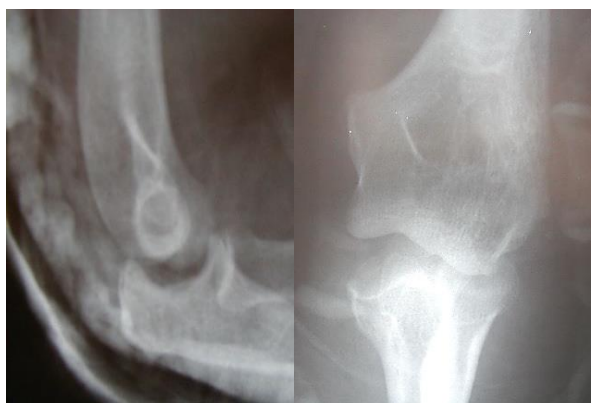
Anteroposterior and lateral radiographs of a patient who presented to the clinic with a non-concentric reduction after an initial elbow dislocation without associated fractures
